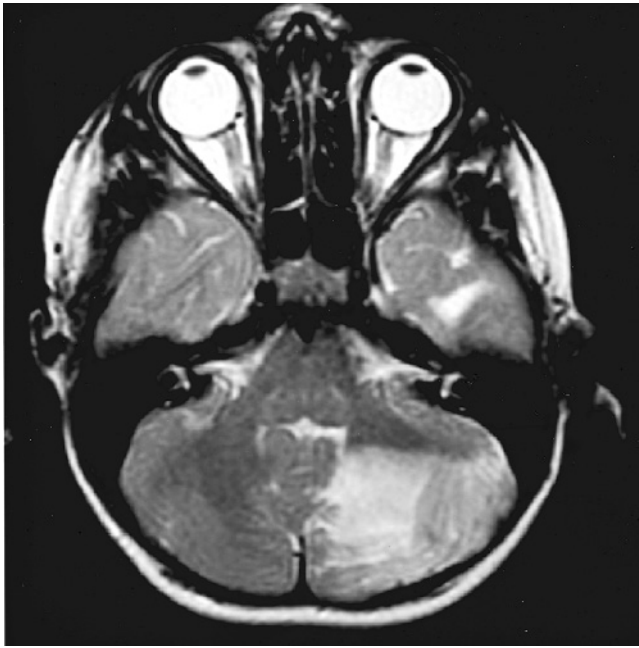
Cerebellar tuber with associated left cerebellar hemisphere hyperplasia on an axial T₂-weighted magnetic resonance image. Courtesy of D. N. Franz, Cincinnati, OH.
